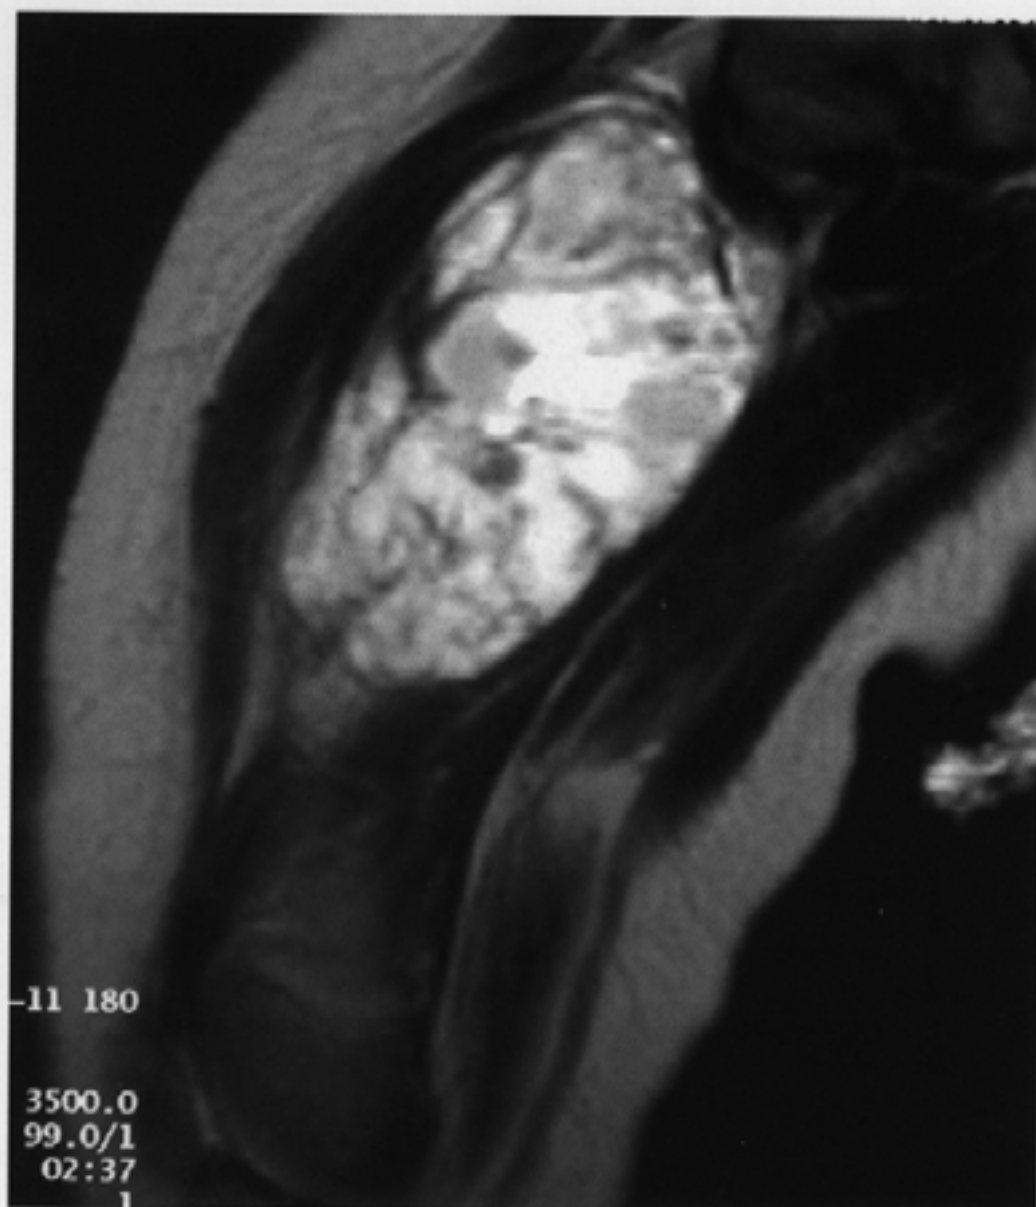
Magnetic resonance imaging (MRI) showing an 8×5×5 cm heterogeneous mass with central cystic-necrotic areas. a) T1 weighted coronary image after Gd-DTPA enhancement, b) T2 weighted coronary image.
